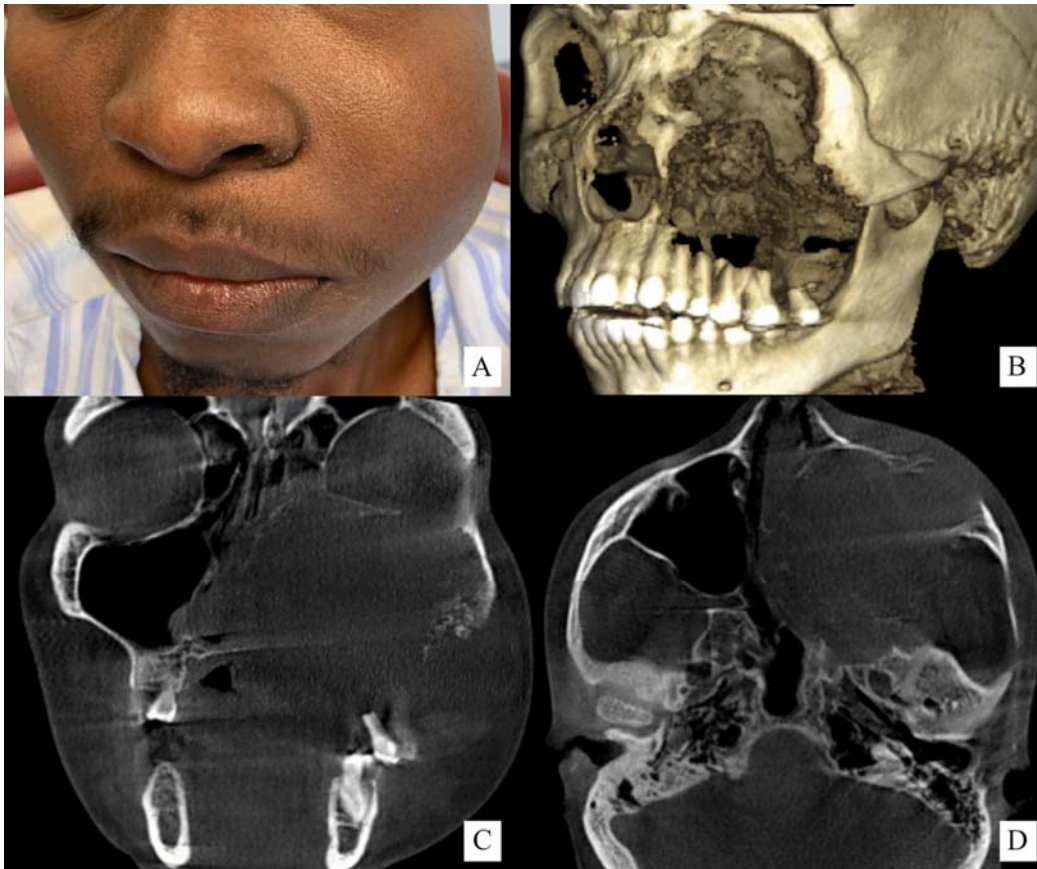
Case 10: (A) Clinical image showing a large swelling involving the left side of the face. (B) 3D reconstruction (C) coronal and (D) axial CBCT imaging showing a lesion of soft tissue density infiltrating the left maxillary sinus. The lesion caused significant expansion with destruction of the left lateral nasal wall, inferior orbital border, hard palate, zygoma and maxillary alveolus.
